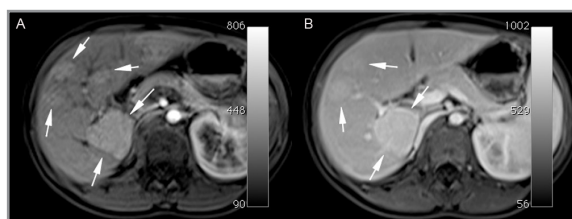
(a, b). Six year old girl with a history of stage II right surrenal neuroblastoma treated with chemotherapy. Liver MRI with T1 weighted images with contrast injection at the early (a) and late (b) arterial phases, performed four years after the treatment, displays multiple hepatic nodules, from 10 to 35 mm large (Case 2). Characteristically, the lesions are isointense on T1-weighted images and slightly hyperintense on T2-weighted images. Early arteriel phase enhancement and late venous phase contrast fixation are also characteristics for FNH.
